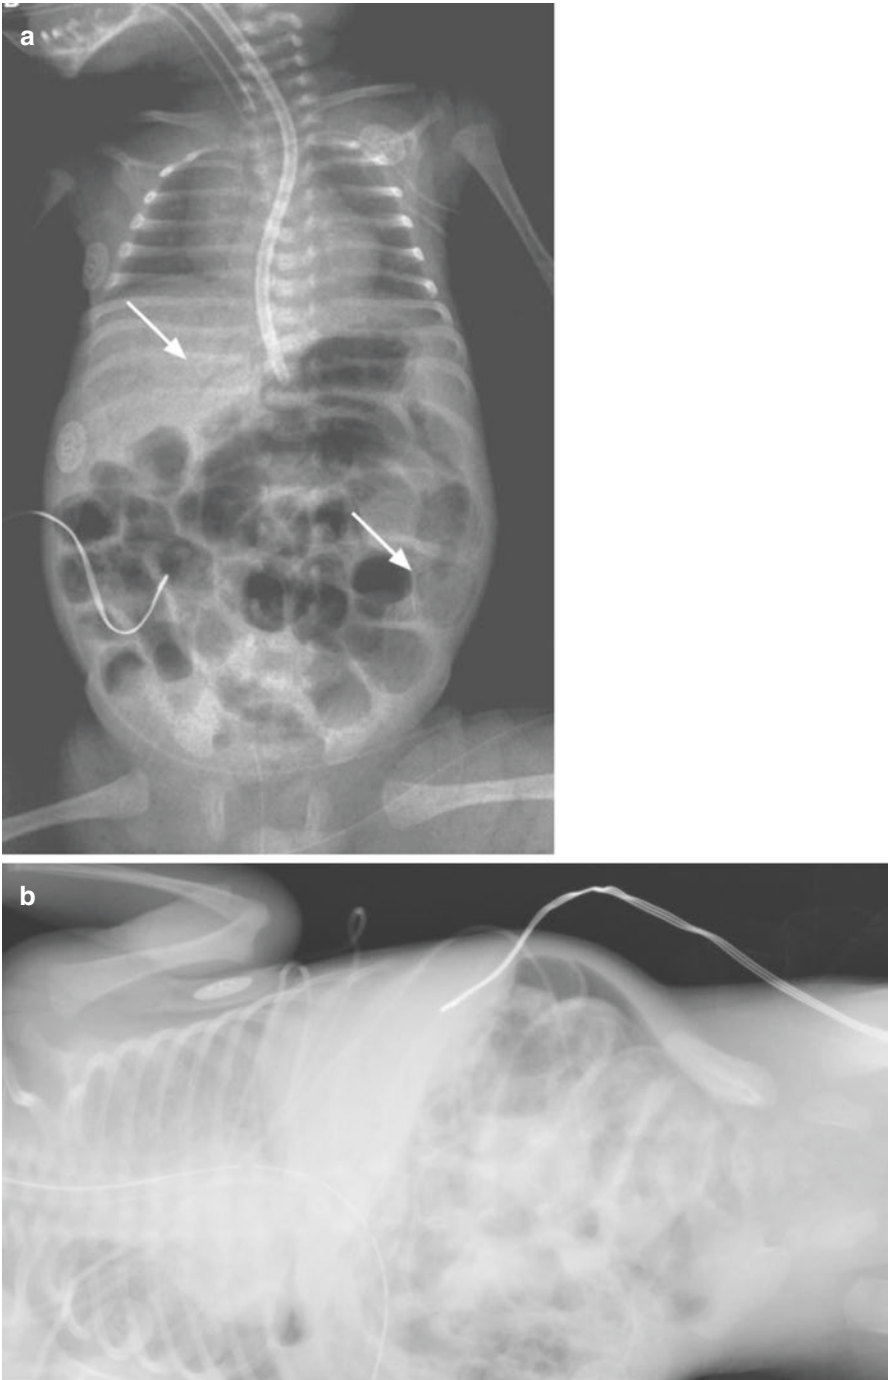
Radiographic findings of necrotizing enterocolitis. (a) Pneumatosis intestinalis (lower arrow) and portal venous gas (upper arrow); (b) free intraperitoneal air as seen on a decubitus radiograph. Used with permission from [23]
